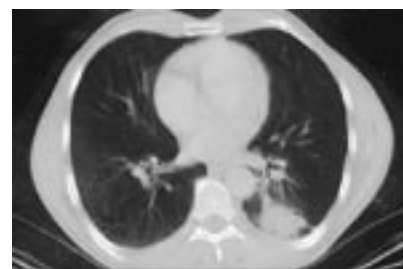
CT scan showing a mass in the left lung.
